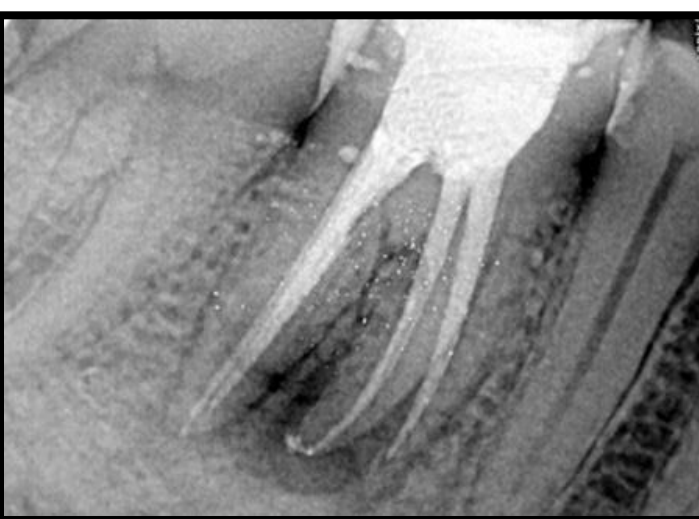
obturation radiograph
